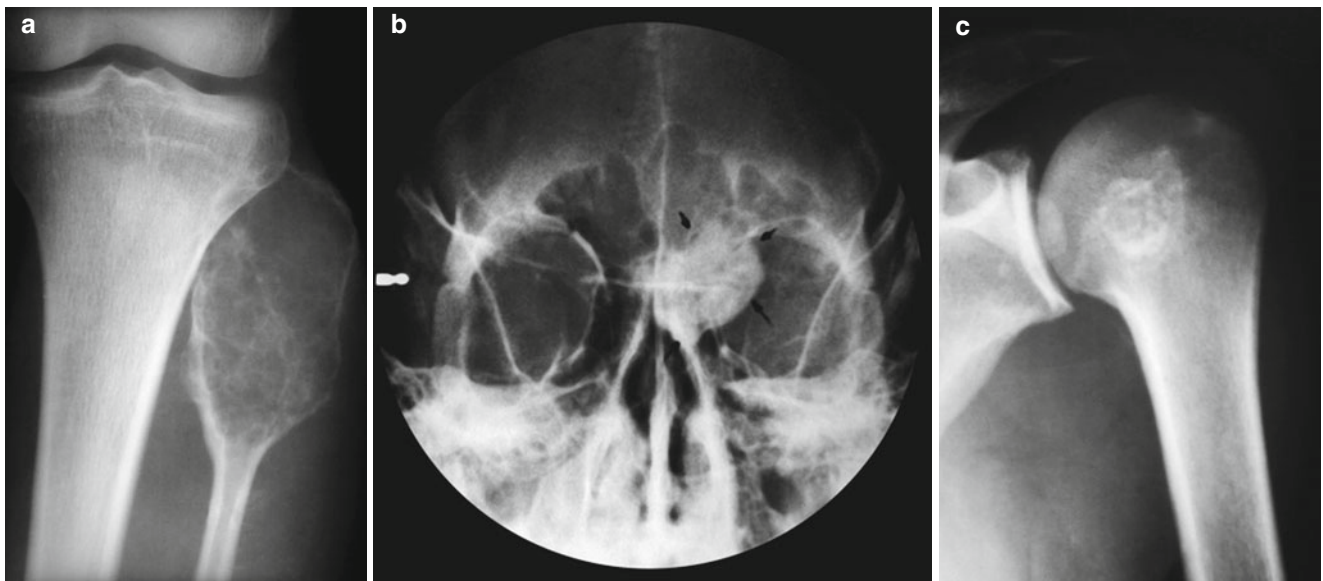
The radiographic appearance is quite varied. The lesion may be radiolucent (a), radiodense (b), or mixed (c)
